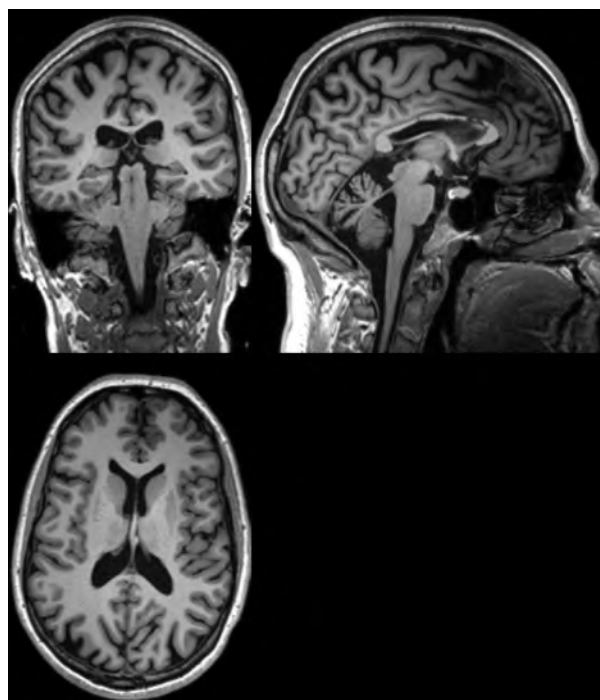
Example of an MRI image. The different tissues (grey matter, white matter, skin, air) can clearly be distinguished.
